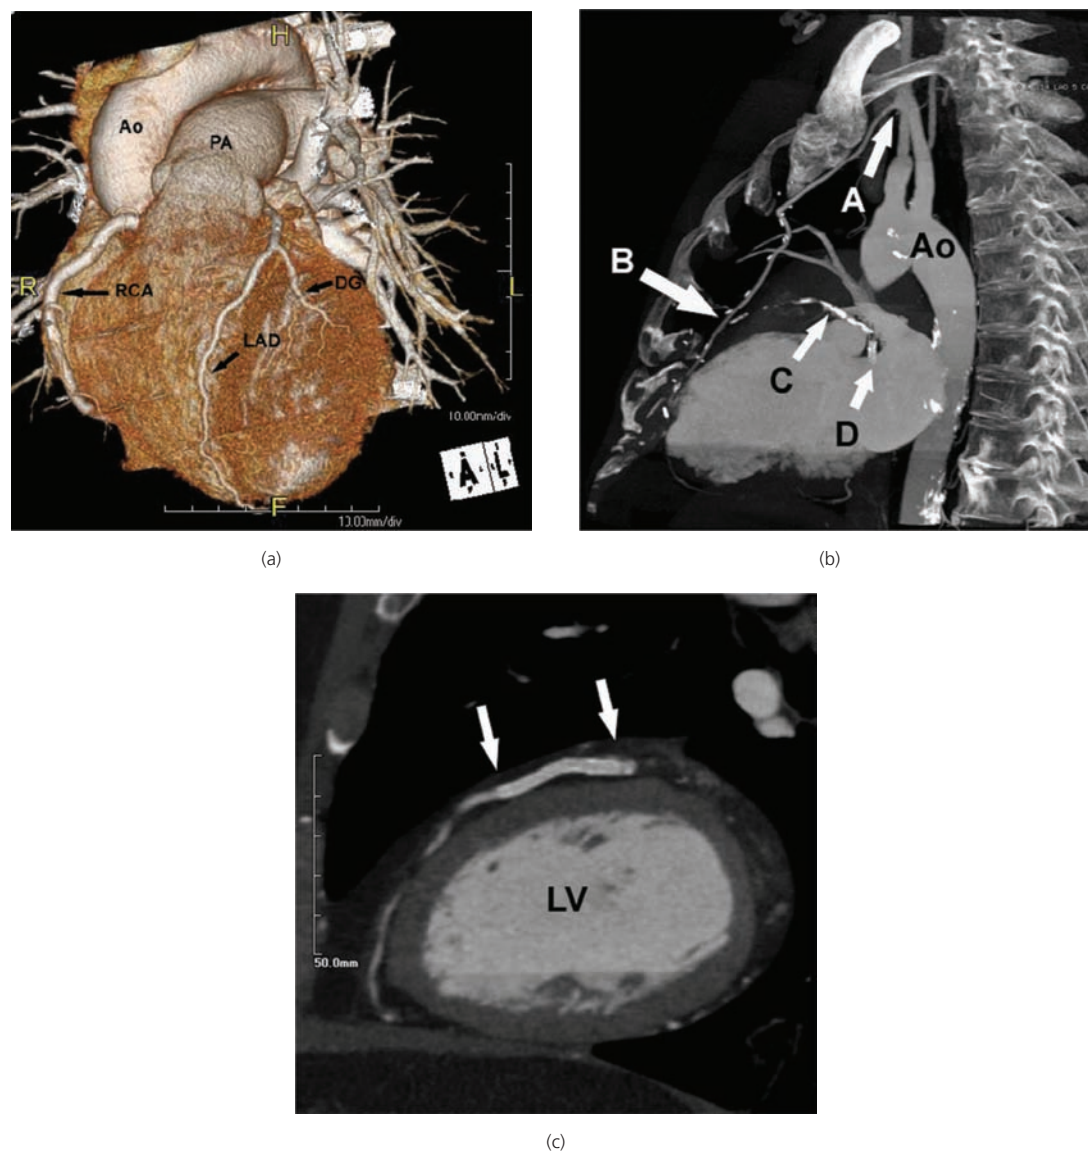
(a) Three-dimensional 64-slice cardiac computed tomography scan. (Ao, aorta; PA, pulmonary artery; RCA, right coronary artery; LAD, left anterior descending artery; DG, diagonal artery.) (b) Cardiac computed tomography scan showing course of patent left internal mammary artery (A and B) supplying the native distal LAD artery. The proximal and mid-LAD artery is heavily calcified (C) and there is a visible stent in the left circumflex artery (D). There is also calcification of the aortic arch and descending aorta (Ao). (c) Patent coronary stent (between two arrows) in left anterior descending artery.
